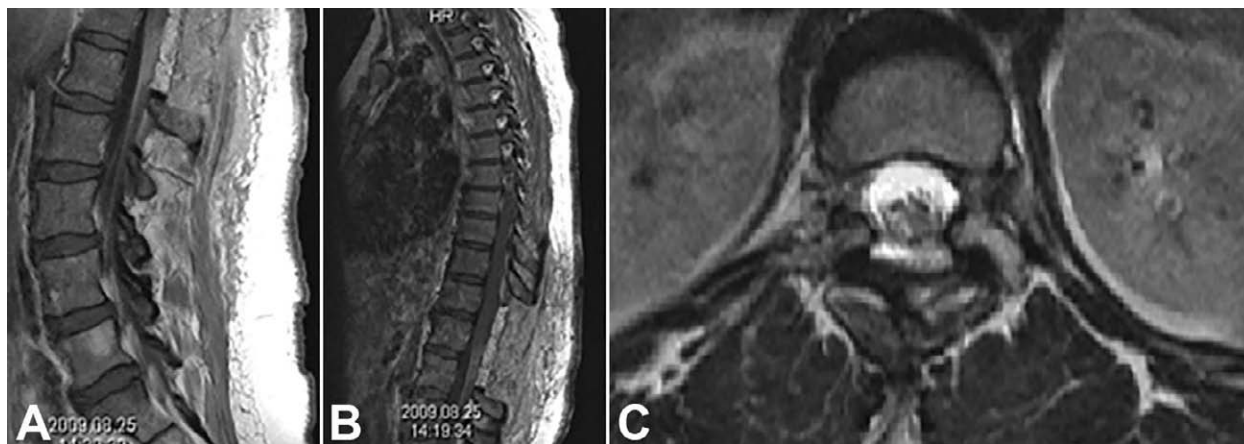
Postoperative T1-weighted post-contrast sagittal magnetic resonance imaging (MRI) of the lumbar (A) and thoracic (B) spine showing complete tumor resection; axial T2-weighted MRI of the resection cavity at T12 level (C).
